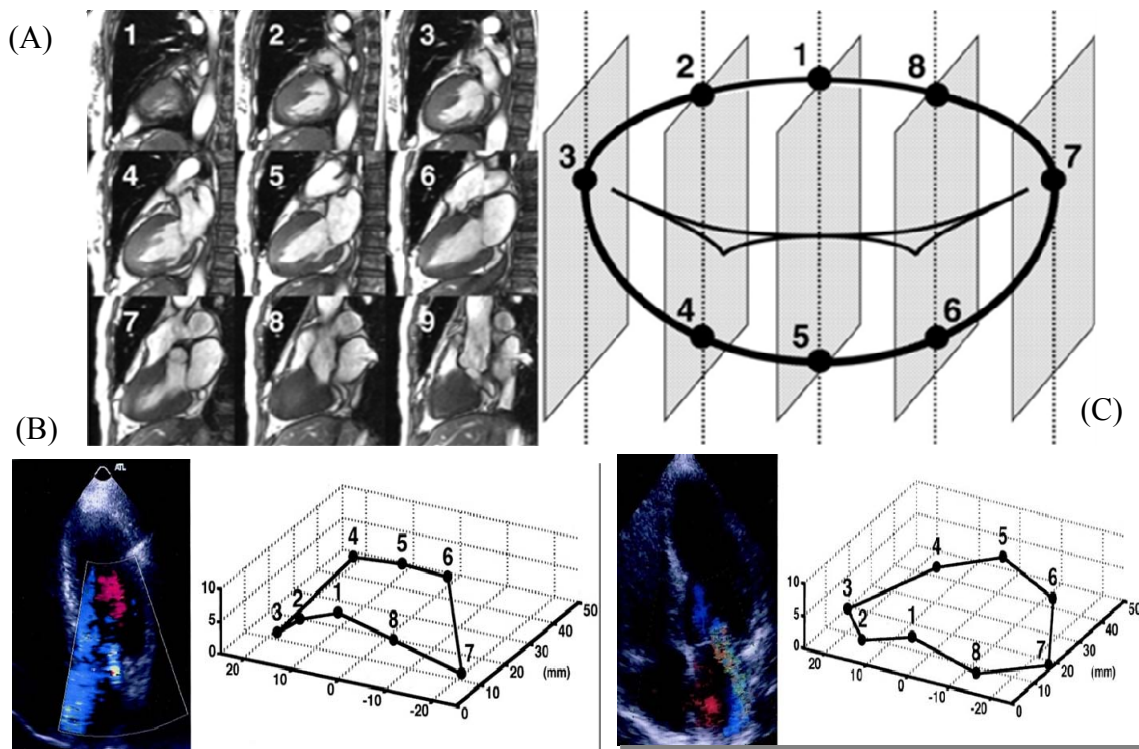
Mitral annular non planarity in normal and chronic ischemic mitral regurgitation patients was assessed using multi plane echocardiography at different points on the mitral annulus shown in (A). (B) Normal subjects without ischemic mitral regurgitation had a significant saddle shape of the mitral annulus; (C) Chronic ischemic mitral regurgitation subjects had a flattened annulus. Figure reproduced from Kaji, S. et al. Circ 2005; 112:I-409 -414I.[106]
